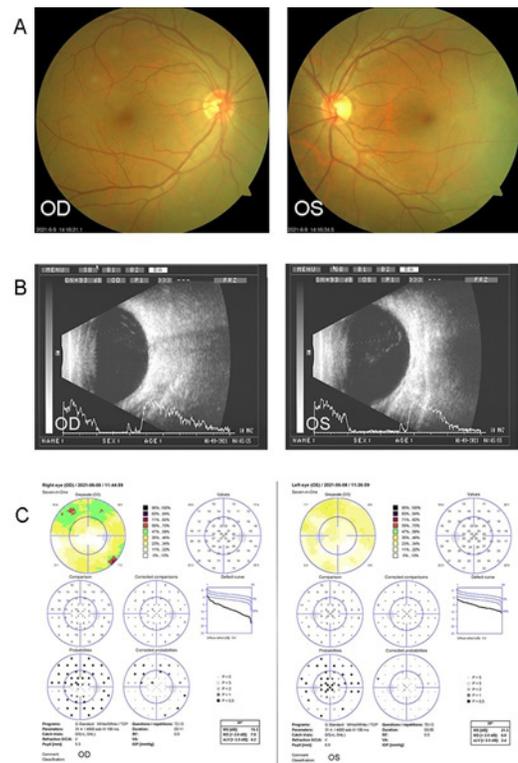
(A): Fundus photography. Funduscopic examination revealed clear fundus, ruddy retina and no hemorrhage in vitreous cavity, a cup disc ratio of 0.5 in the right eye, and the optic disc was normal in the left eye. (June 09, 2021). (B): B-scan ultrasound. B-scan ultrasound showed an inhomogeneous weak dough-like echoes in the vitreous cavity of the right eye. (June 09, 2021). (C): The central visual field of the right eye was defective, and the left eye was approximately normal. (June 08, 2021).
